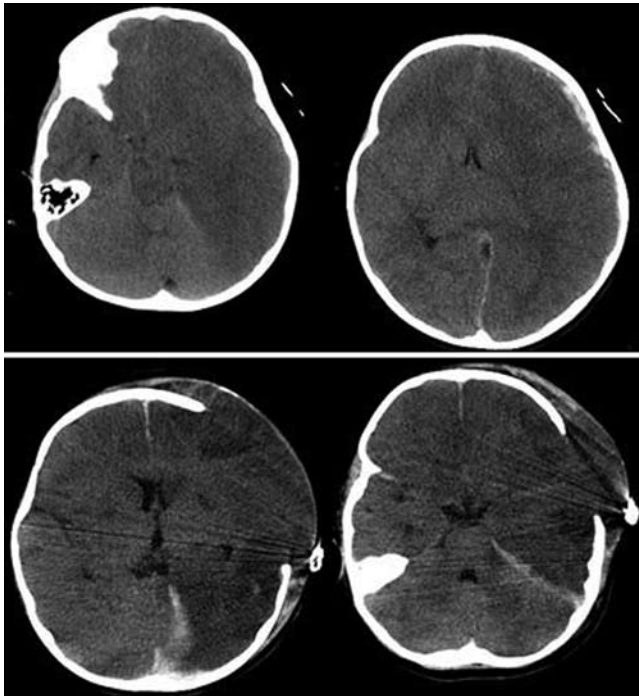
Case 4. Preoperative (upper) and postoperative (lower) CT scans. Upper: Initial noncontrast head CT scans of a 23-month-old girl showing left hemispheric edema, midline shift, effacement of the basal cisterns, and a small left-frontal SDH. Lower: Images obtained 48 hours after left decompressive craniectomy showing resolution of midline shift and opening of the basal cisterns. Note herniation of brain tissue through the craniectomy defect, as well as ischemic left frontal and occipital lobes.
